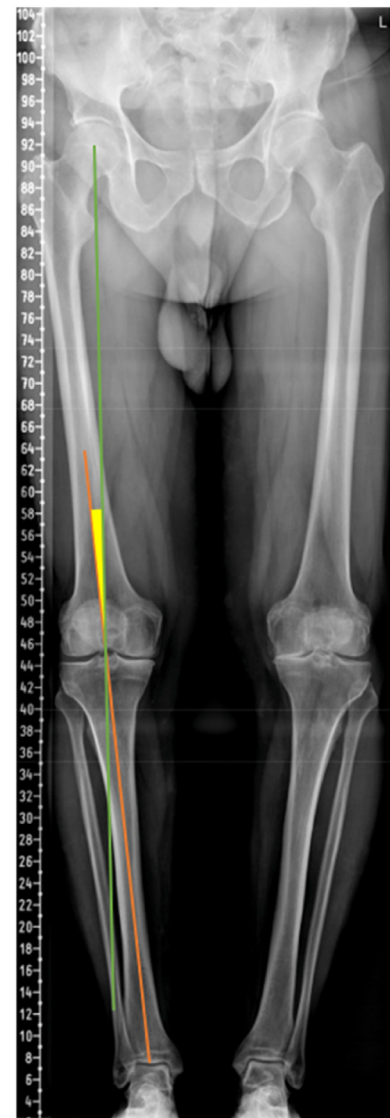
Radiographic measurement of the HKA angle. The green line is drawn from the center of the femoral head to the femoral intercondylar notch, while the orange line from the tibial interspinous point to the tibial mid-plafond. The angle between these lines (marked yellow) is the HKA angle (hip-knee-ankle angle).
